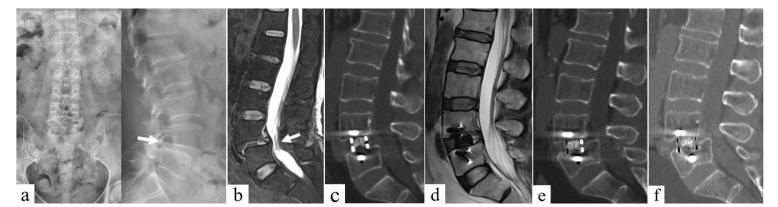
(a), preoperative X-ray radiographs revealed II° spondylolisthesis of L4; (b), preoperative MRI revealed spinal canal stenosis at L4-5; (c), 1day postoperative 3D-CT revealed good positioning of cage within the disc space without evidence of endplate violation or cage subsidence; (d), 1day postoperative MRI revealed clearly expansion of the spinal canal; (e), emergency 3D-CT (10 days postoperatively) revealed a non-displacement coronal fracture of the L5 vertebrae and cage subsided into the fractured vertebrae; (f), 12 months postoperatively, the 3D-CT revealed the vertebrae fracture healed and the successful fusion was also achieved.
